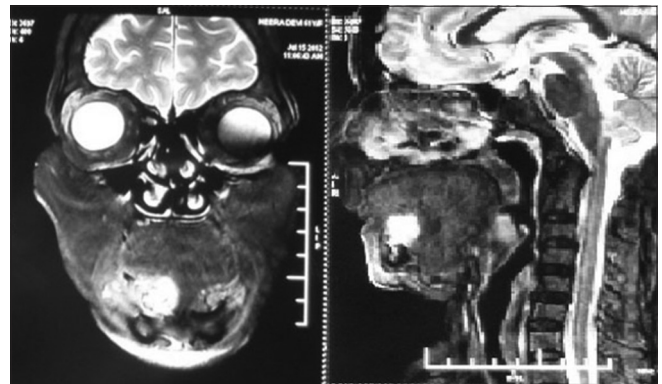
Magnetic resonance imaging of the lesion
